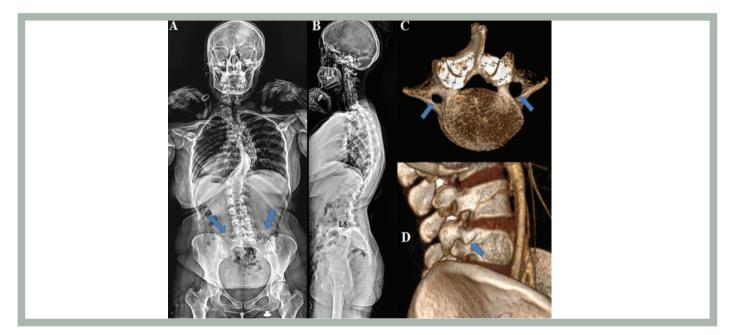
Radiological examinations of a 33-year-old female patient who presented to our clinic for surgical treatment. Preoperative radiological examination revealed a transverse foramen anomaly in the L5 vertebra (arrows). The spinal deformity is shown in (A) as an AP radiograph of the entire spine and in (B) as a lateral radiograph. In the (C) 3D reconstruction view, bilateral transverse foramen can be seen, which is wider on the left side. In (D), the 3D volume rendering view in the lateral plane shows that the vascular structure does not pass through the transverse foramen
